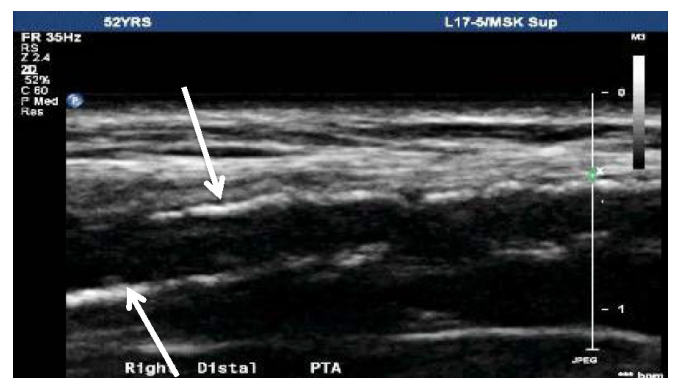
Ultrasound conducted for ankle sprain of Athlete 1 [Note arrows show echogenic intima-media thickening (beads) in the distal posterior tibial artery]
